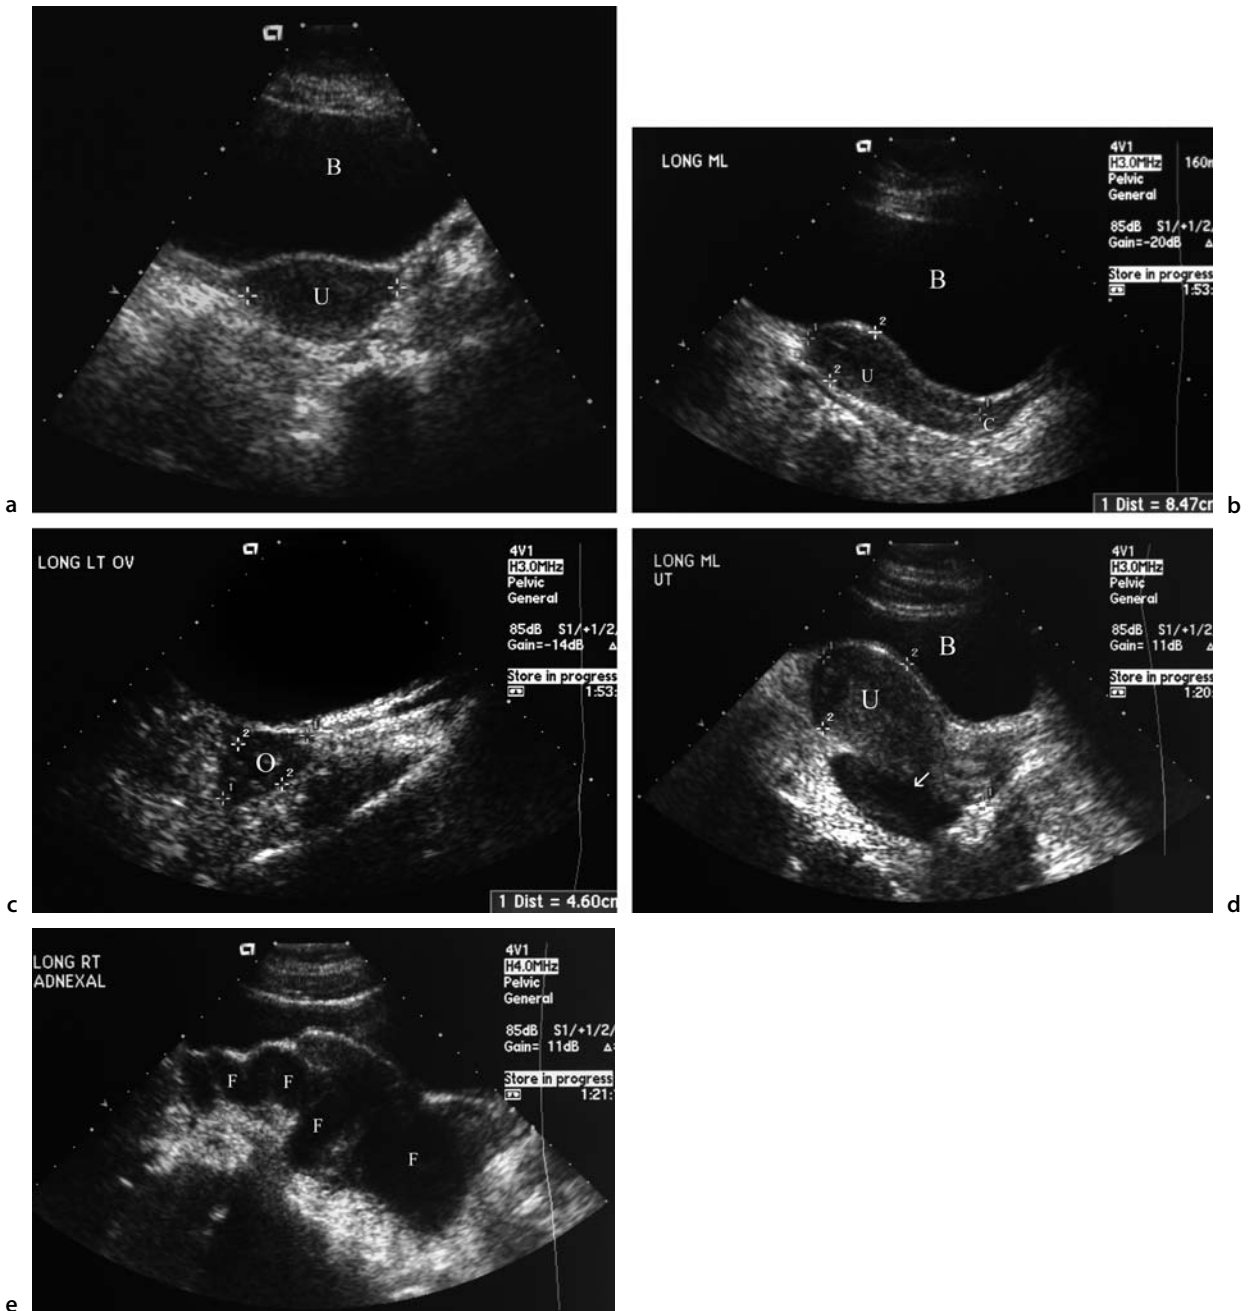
Ultrasonography of the female pelvis
